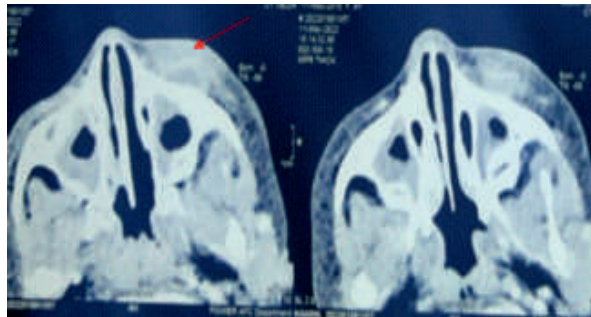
Location of abscess seen in axial section of contrast enhanced computed tomogram
